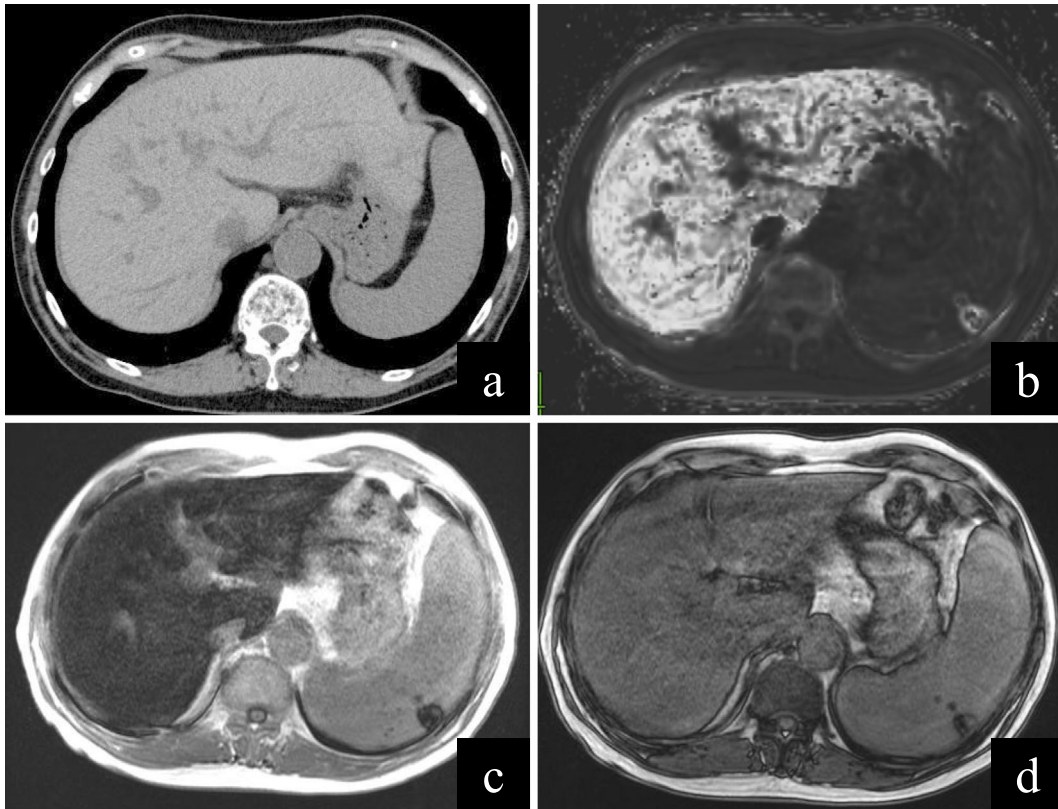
Findings from (a) plain computed tomography, (b) R2* mapping, and (c) in-phase and (d) out-of-phase T1-weighted magnetic resonance imaging. The liver parenchyma also exhibited a markedly elevated signal on the R2* map, with a significantly low signal on the in-phase image (vs. the out-of-phase image), which reflected iron deposition.
